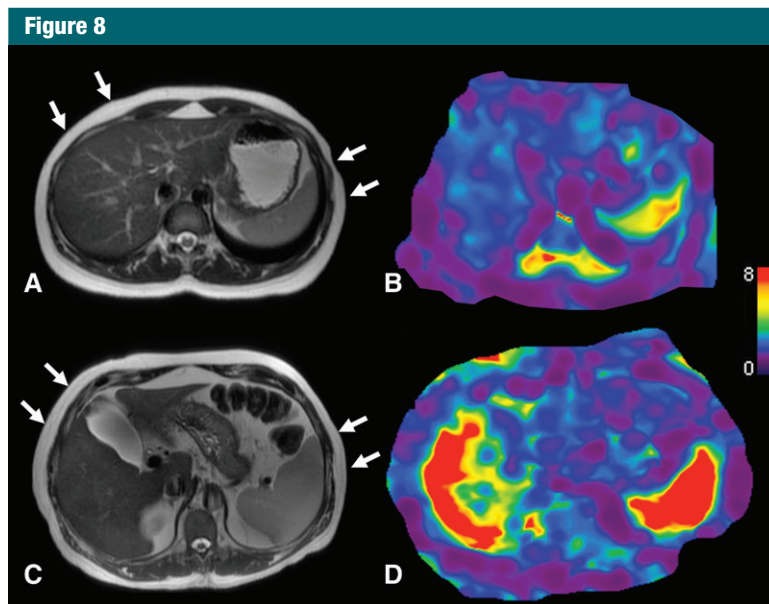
A, Transverse T2-weighted half-Fourier acquisition single-shot turbo spin-echo, or HASTE, MR anatomic image with arrows indicating actuator position and, B, transverse stiffness map in a 27-year-old healthy woman with normal liver stiffness (2.1 kPa) and spleen stiffness measured at 4.3kPa. C, Transverse anatomic image with arrows indicating actuator position and, D, transverse stiffness map in a 61-year-old female patient with cirrhosis (secondary to chronic hepatitis C virus infection) and clinically significant portal hypertension (hepatic venous pressure gradient of 15 mmHg) demonstrate elevated liver stiffness (7.5 kPa) and spleen stiffness (9.9 kPa).
